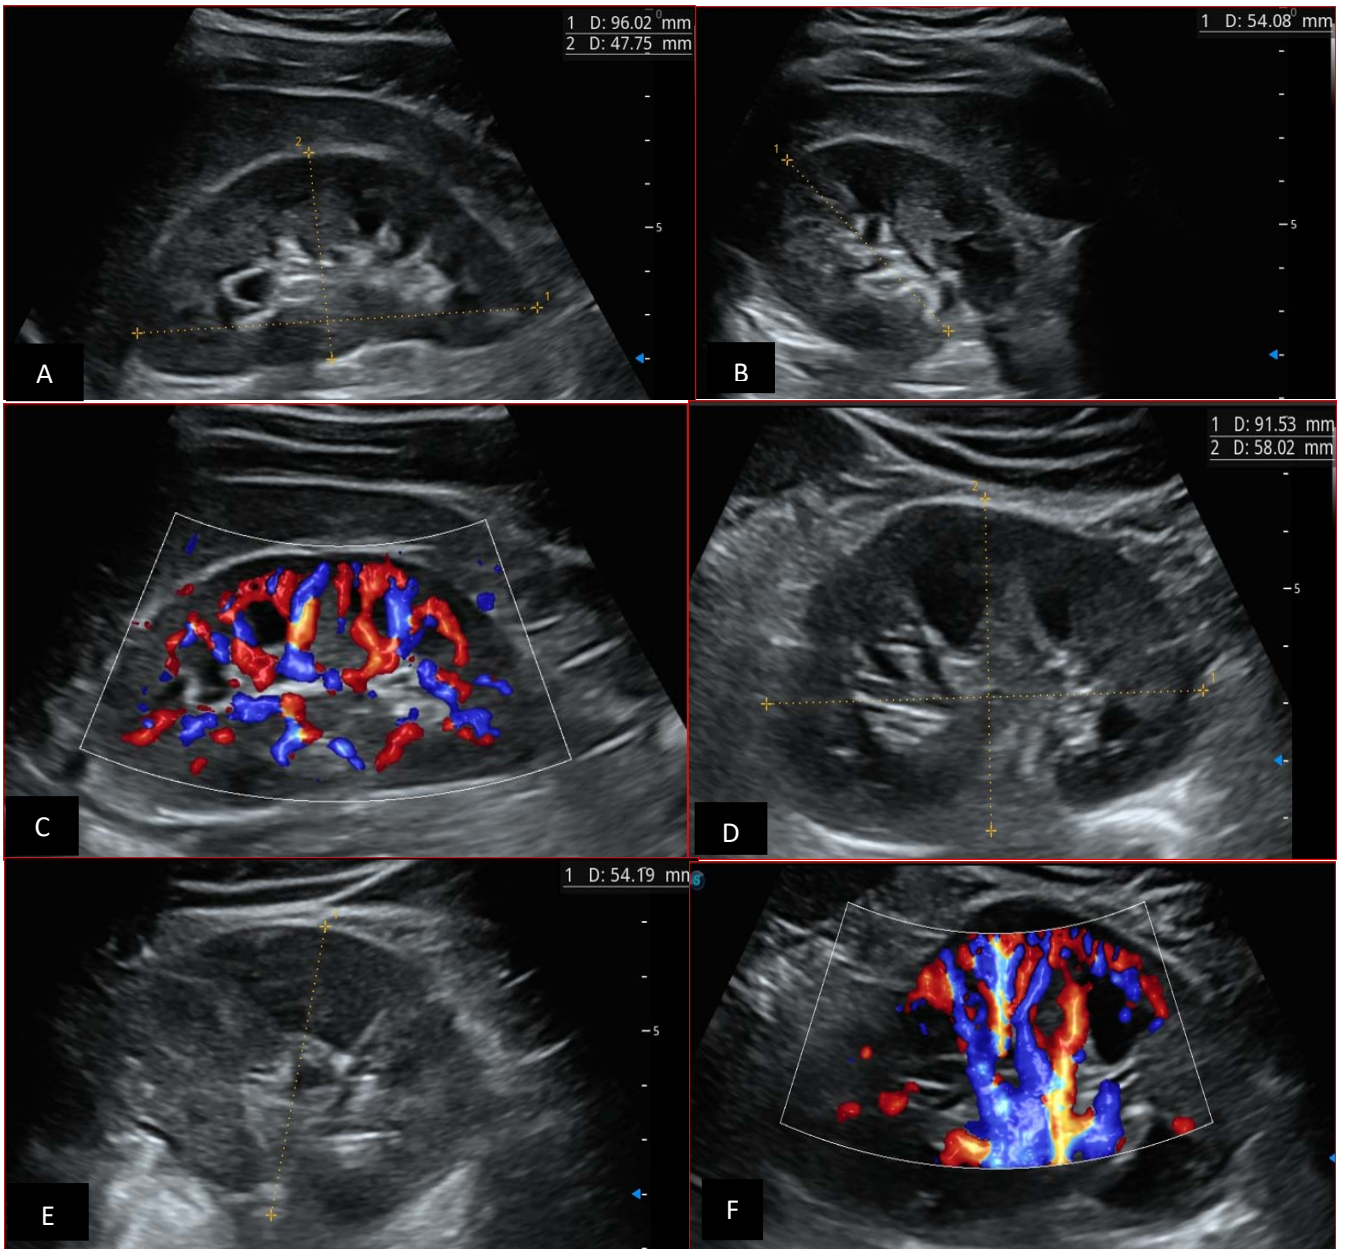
7-year-old patient with normal renal Doppler ultrasound examination: Images A and B: normal morphology of the right kidney in B-mode; Image C: normal vascularization of the right kidney in color Doppler mode. Images C and D: represent a normal morphology of the left kidney in B mode. Image F: represents normal vascularization of the left kidney in color Doppler mode. Source : Dr. Frederick Tshibusu Tshienda database.
